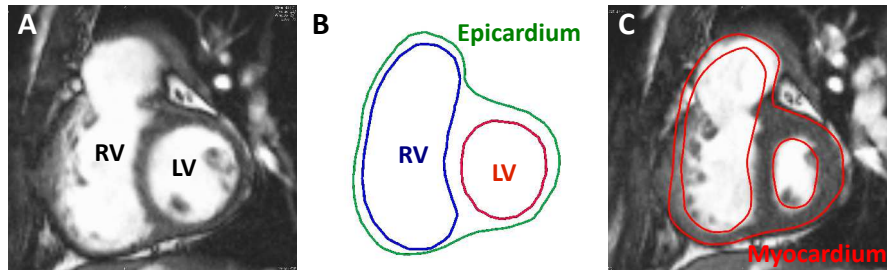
Segmentation of the compact bi-ventricular myocardium of patient 1 from cine MRI. A- Cine MRI. B- Contours at end-diastole. C- Tracked myocardium contour at end-systole.
